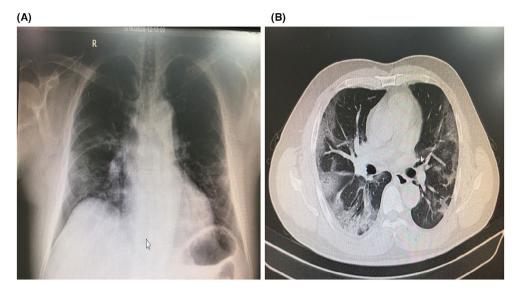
Chest radiograph of Filipino patient. A, Chest X-ray of male Filipino patient showed bilateral middle and lower zones heterogeneous opacities with preserved lung marking as well as several reticulation more on the right side; B, CT scan chest showed bilateral peripherally located patchy areas of ground-glass opacity with thickening of interlobular setae and intralobular septal thickening given the crazy paving pattern, areas of vascular dilation and minimal traction bronchiectasis are also seen
